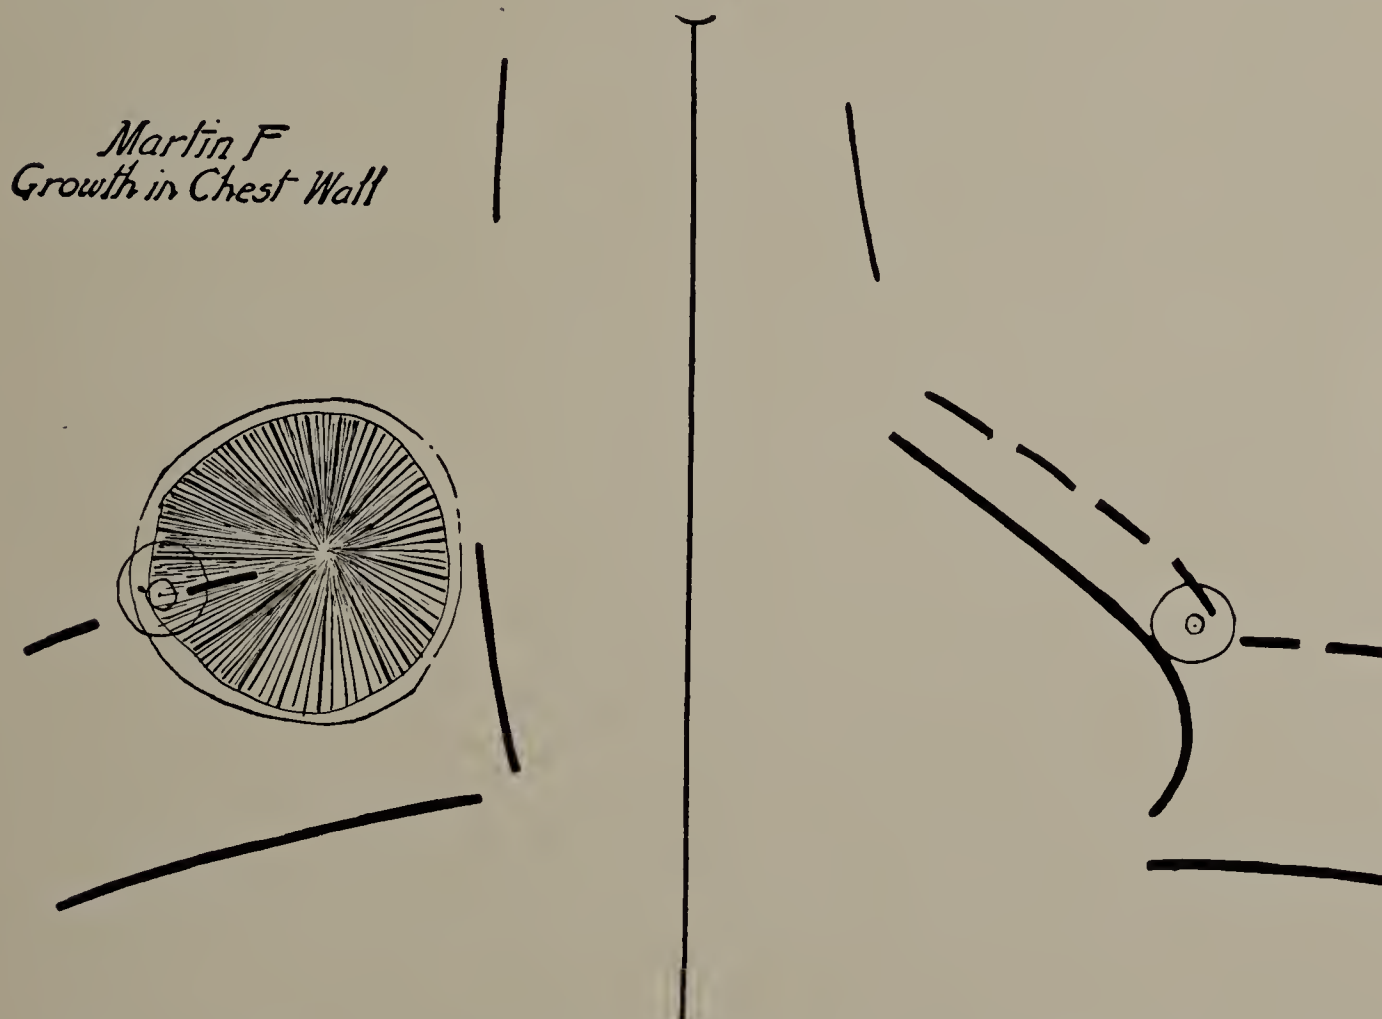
Martin F. The shaded area on the right chest represents the size and position of an indurated mass which was prominent when the chest was inspected and cast some shadow on the screen. The outline of the diaphragm and heart are X-ray outlines. (Cut one-third life size.)
